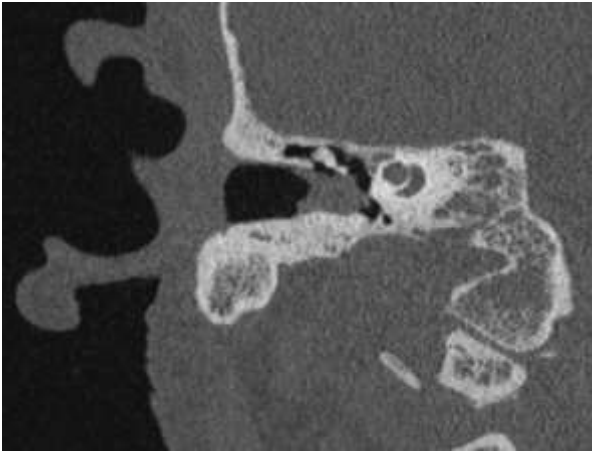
CT scan of the right petrous bone demonstrating a globular, focal soft-tissue mass bulging into the tympanic cavity, with associated scutum erosion and displacement of the ossicular chain
